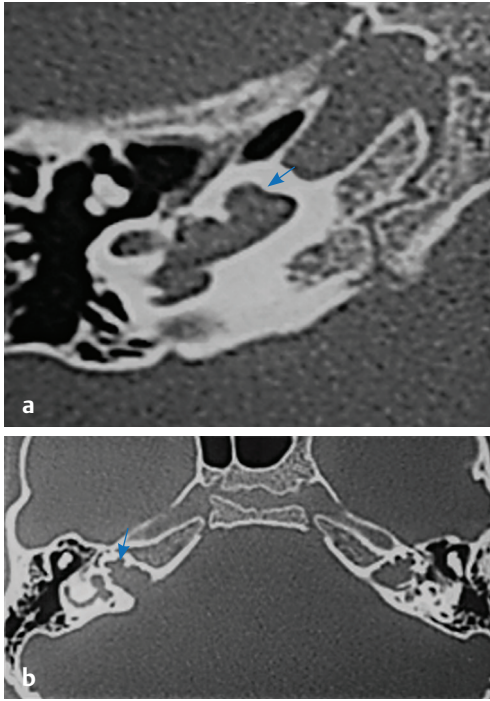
HRCT temporal bone, bone window, axial sections show CVM type III (blue arrow) with (a) type IIIa (absent modiolus, lamina cribrosa present) and (b) type IIIb (absent modiolus and absent lamina cribrosa).
